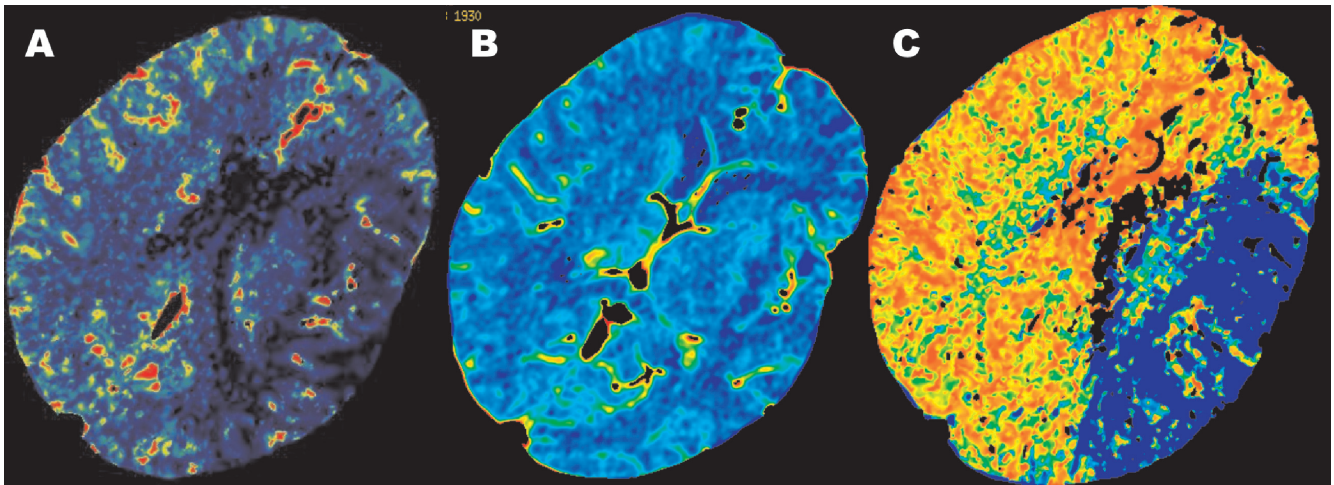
Female, 84 years, acute (1 hour from the symptoms onset) ischemic stroke in left middle cerebral artery circulation territory. Standard CT perfusion maps. A - CBF. B - CBV. C - MTT.
